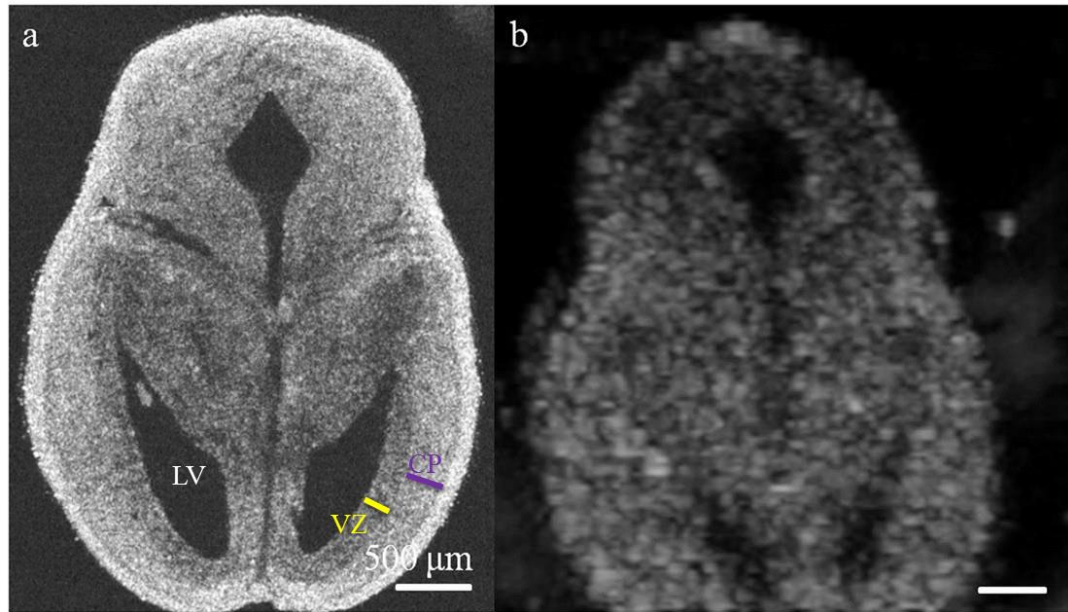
Comparison between images obtained using OCT and ultrasound imaging. 2D cross-sectional images obtained using (a) OCT (b) ultrasound imaging. Scale bar, 500μm. LV – Lateral ventricles, VZ – Ventricular zone, CP – Cortical plate. [195].
